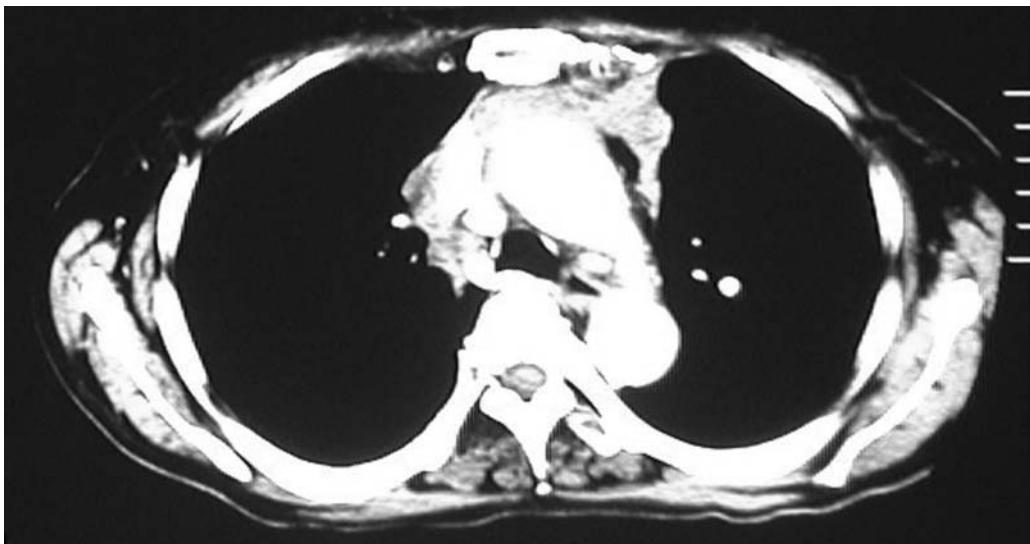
CT scan of the thorax after chemotherapy. The CT scan shows a dramatic decrease in the size of the anterior mediastinum mass as well as resolved SVC syndrome, and the mass effect of the aorta disappeared after high doses of methylprednisolone containing cisplatin and adriamycin for three cycles.
